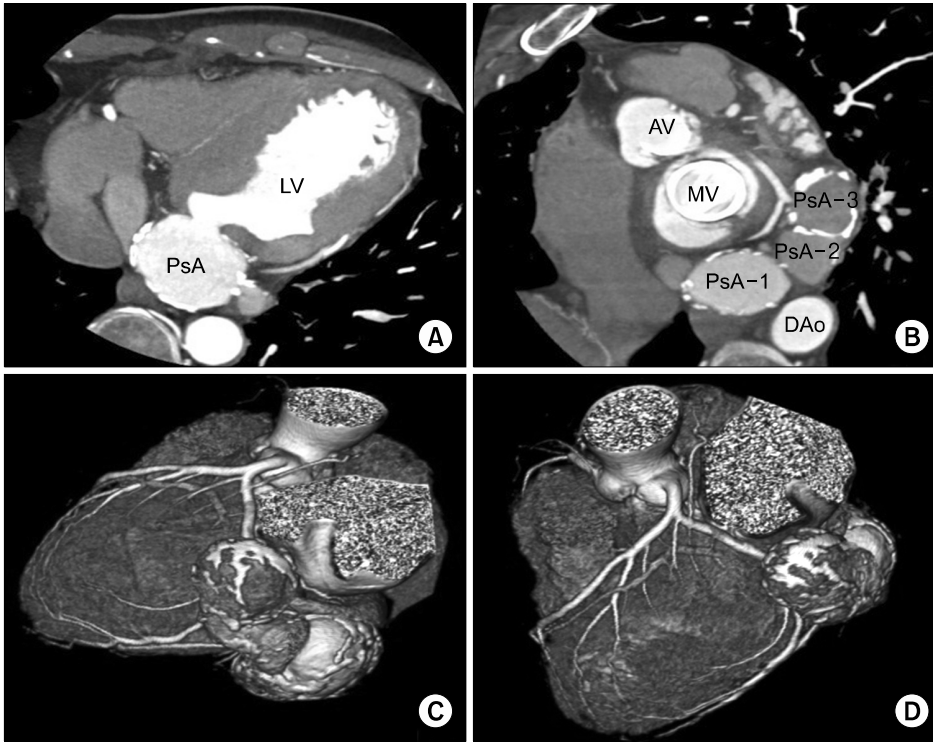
Preoperative coronary computed tomography (CT) angiography. (A) The location of the leak in the left ventricle is the sub-mitral valve prosthesis area. (B) Three large lobulated aneurysms are seen bulging from the base of the left ventricle with calcified walls. (C, D) Three-dimensional reconstruction of preoperative coronary CT angiography. PsA, pseudoaneurysm; LV, left ventricle; AV, aortic valve; MV, mitral valve; DAo, descending aorta.
